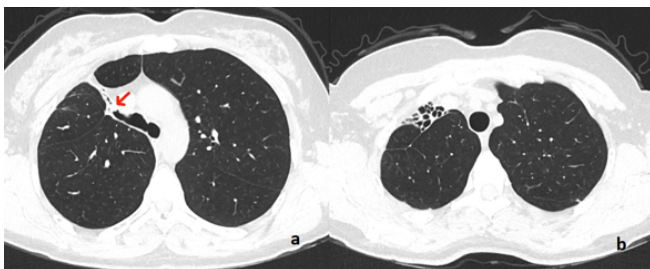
(a) Axial view of computed tomography showing the endobronchial mass (arrow), (b) bronchiectasis of the right upper lobe.
